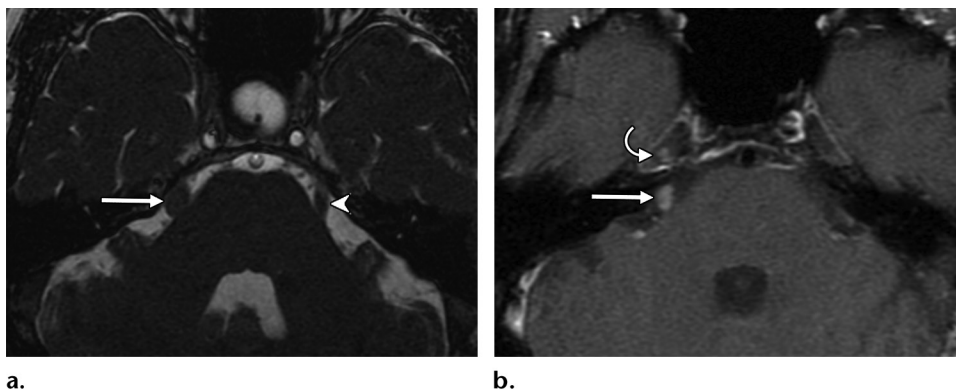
Small clinically diagnosed CN V schwannoma in a 64-year-old man. (a) Axial fast imaging employing steady-state acquisition MR image shows expansion of the cisternal segment of right CN V (arrow). The contralateral CN V (arrowhead), which has a normal anatomy, exits the lateral pons and courses through the prepontine cistern into the Meckel cave. (b) Axial contrast-enhanced fat-suppressed T1-weighted MR image shows an enhancing right cisternal CN V schwannoma (straight arrow), with extension into the Meckel cave (curved arrow).
